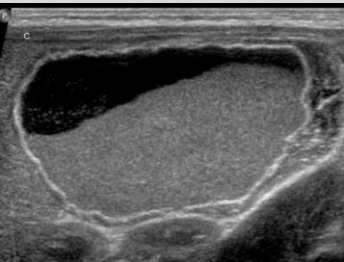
Abdominal ultrasound in a neonate with an antenatal diagnosis of an intra-abdominal cyst shows a cyst in the right upper abdomen with a fluid-debris level on post-natal US. A torsed haemorrhagic ovarian cyst was found at surgery.
